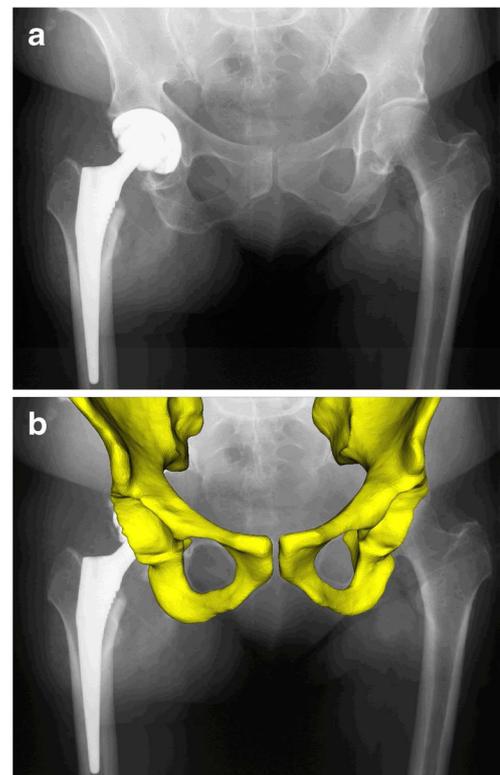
To estimate the cup orientation, the 2D/3D reconstruction method first reconstructs a patient-specific 3D model from the X-ray radiograph by matching the statistical shape model of the pelvis to the X-ray radiograph. a The input X-ray radiograph. b The superimposition of the reconstructed 3D surface model (yellow) on the X-ray radiograph
